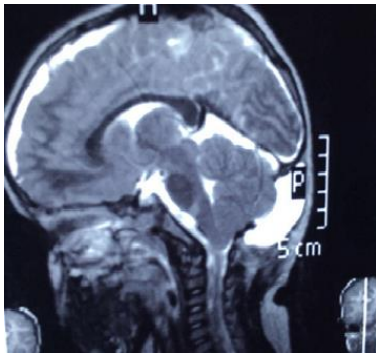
post op.T2 sagittal brain MRI
